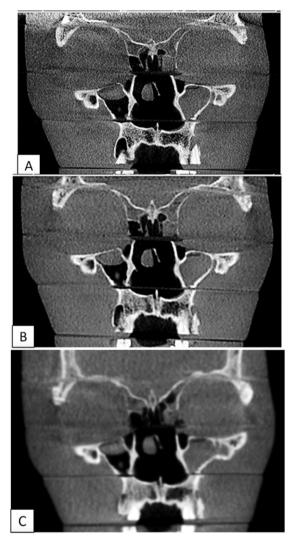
Coronal sections of different CBCT protocols scanned at levels of the maxillary sinus reveal the variations in image quality: (A) Protocol 1, (B) Protocol 2 and (C) Protocol 3.
